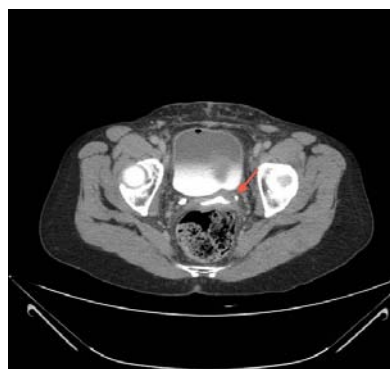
Axial CT-Scan shows contrast extravasations from the left distal ureter and free reflux of contrast material within the vagina (Red Arrow).
